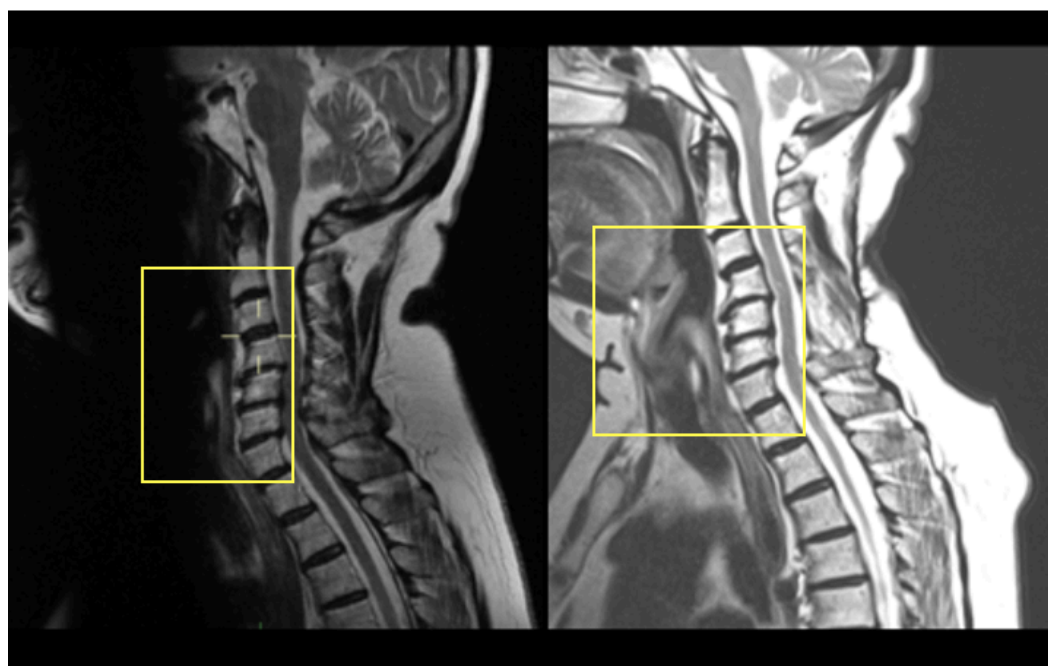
T2-weighted sagittal MRI images demonstrating degenerative cervical myelopathy pre- and post-treatment. Images were anonymised and obtained from the patient with documented consent. When DCM is suspected patients require an urgent MRI of the Cervical spine looking for spinal cord signal changes, increased signal on T2 images, and narrowing of the spinal canal as seen on the left image. The right shows MRI after posterior decompression. The yellow box demonstrates that the spinal cord is no longer compressed following removal of the posterior elements, the signal change indicating cord damage is not reversed.
